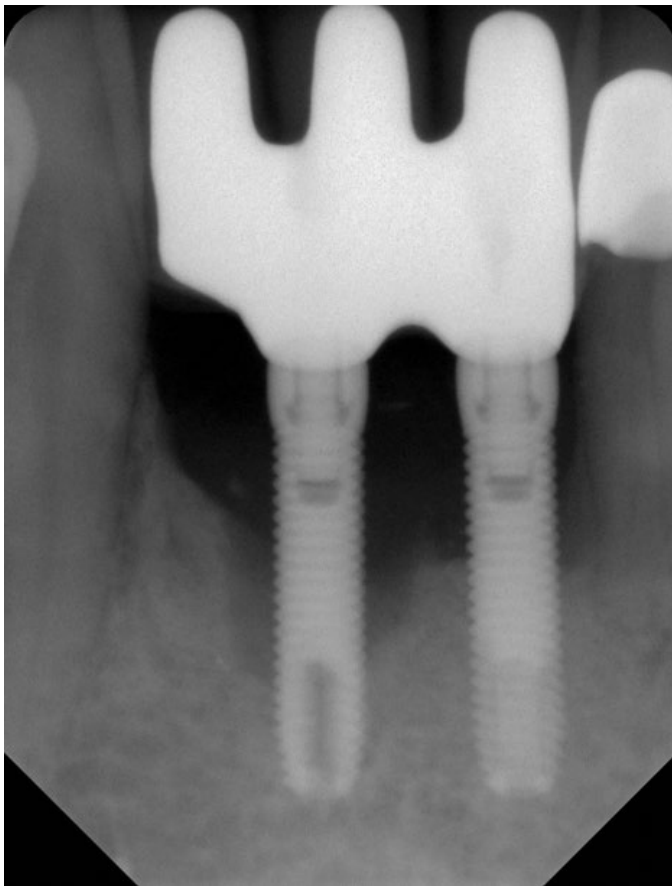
(C) This X-ray reveals extensive bone loss around an implant.
